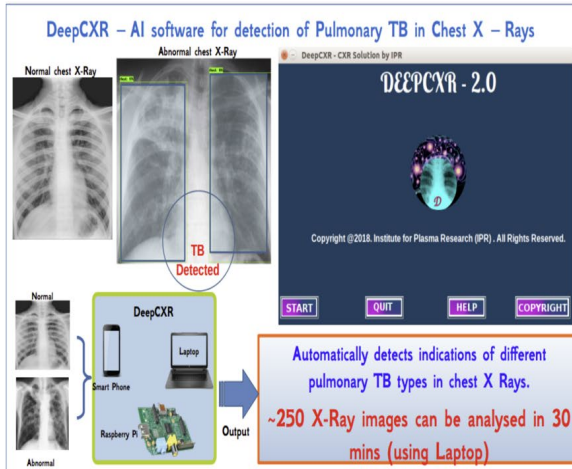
AI Software for Fast Automated Screening of TB using Chest X-Ray Images, in collaboration with ICMR headquarters, Delhi (Robotics, AI & ML, n.d.-b).
